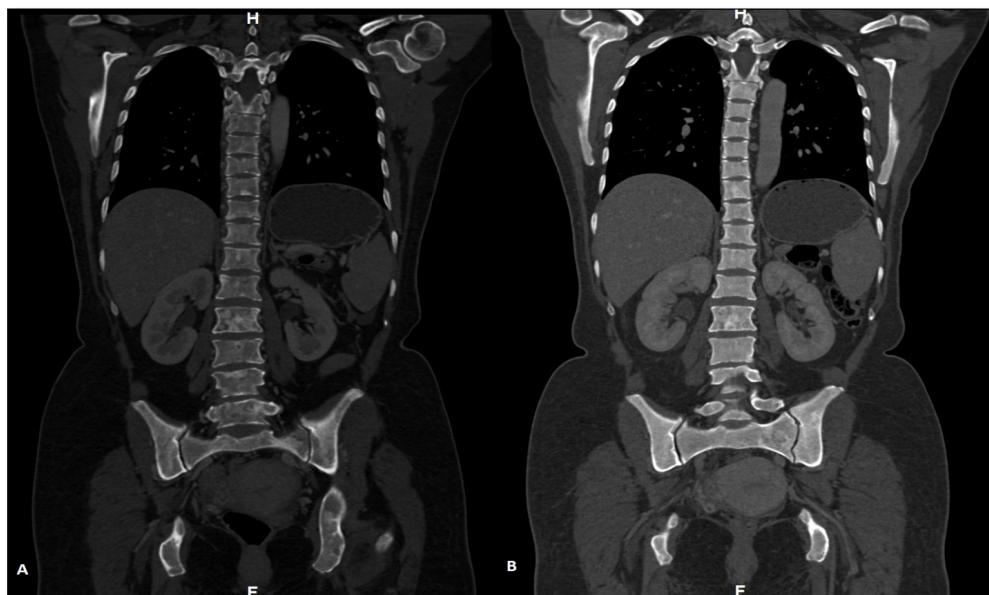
Coronal reformatted images of CT scan of thorax and whole abdomen: (A) CT scan at the time of staging showing diffuse involvement of all visualized bones with mixed lytic sclerotic lesions consistent with bone metastases. (B) Review after four cycles of chemotherapy showing no significant change of the metastatic diseases.
